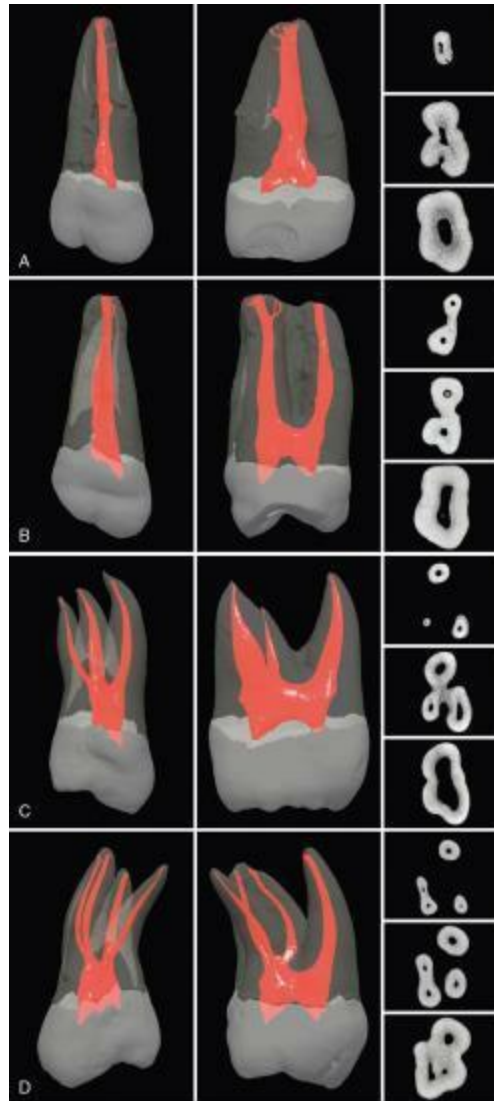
μ CT scans of maxillary second molars; four possible variations. A, Uncommon anatomic presentation of this tooth with one canal. B, Second molar with two canals. C, Second molar with three canals. D, Second molar with four distinct canals. All teeth are shown from both a buccal (vestibular) and a proximal perspective, along with the cross-sectional anatomy at the coronal, middle, and apical levels. (See Video 7.10 online at the Expert Consult site for rotational views of these teeth.)
